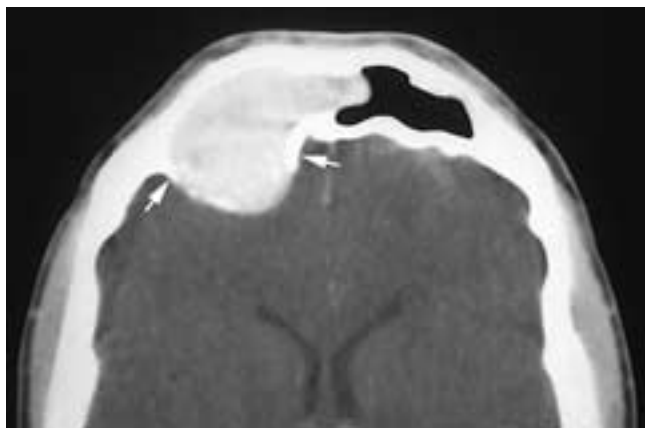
Axial CT scan shows a high-attenuation, expansile right frontal sinus mass that has remodeled the margins of the posterior sinus table (arrows). However, most of the posterior sinus wall is deossified. This patient had a right frontal sinus mucocoele.
